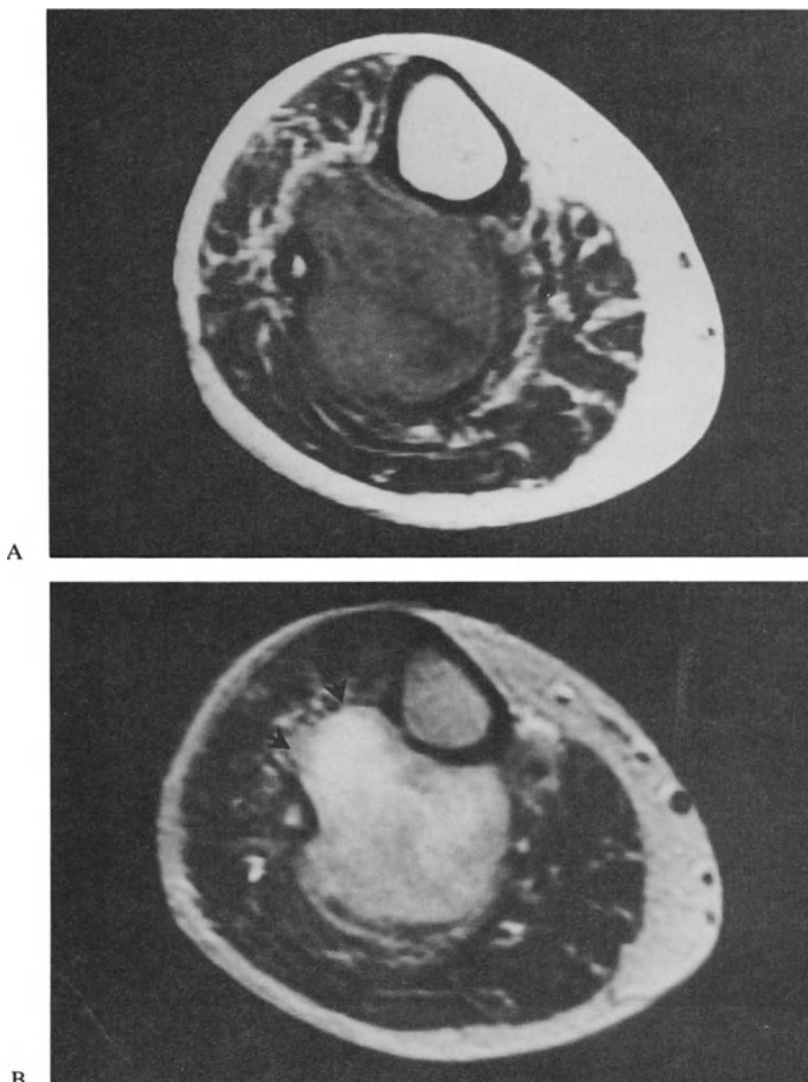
MRI of a malignant fibrous histiocytoma deep in the leg. A T1-weighted spin-echo sequence. The whole tumor has a low signal intensity. B T2-weighted spin-echo sequence. In this sequence the tumor has a high signal intensity, providing excellent contrast with the bone and surrounding muscles. The aggressive nature of the lesion can be inferred from the marked displacement of the interosseous membrane (arrows).
